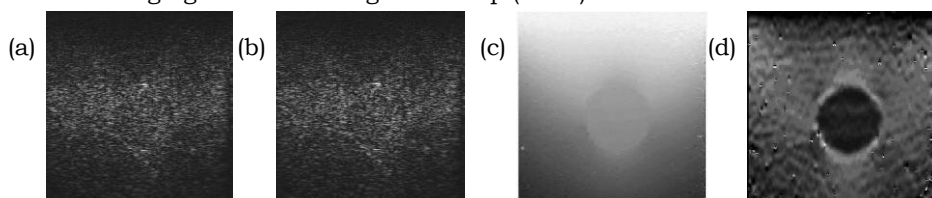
(a) (b) Two sonograms in sequence;
